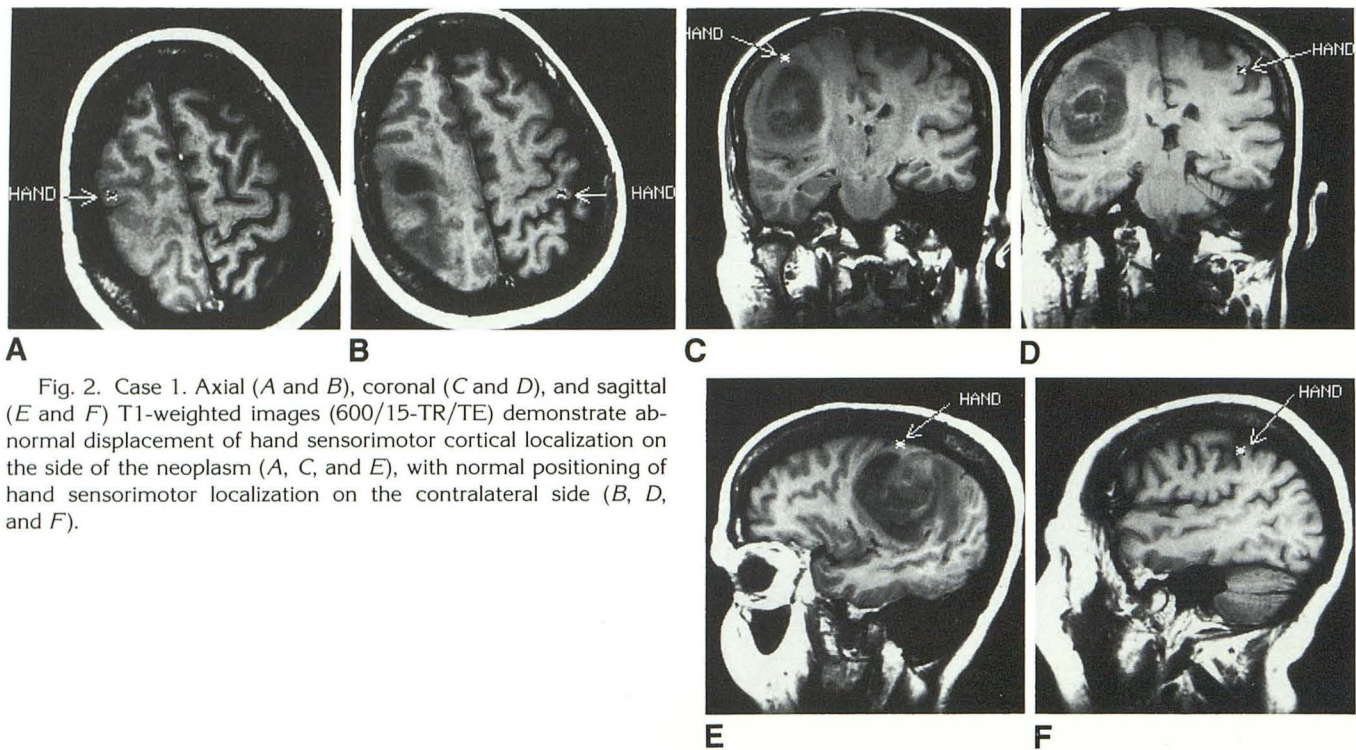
Case 1. Axial (A and B), coronal (C and D), and sagittal (E and F) T1-weighted images (600/15-TR/TE) demonstrate abnormal displacement of hand sensorimotor cortical localization on the side of the neoplasm (A, C, and E), with normal positioning of hand sensorimotor localization on the contralateral side (B, D, and F).
